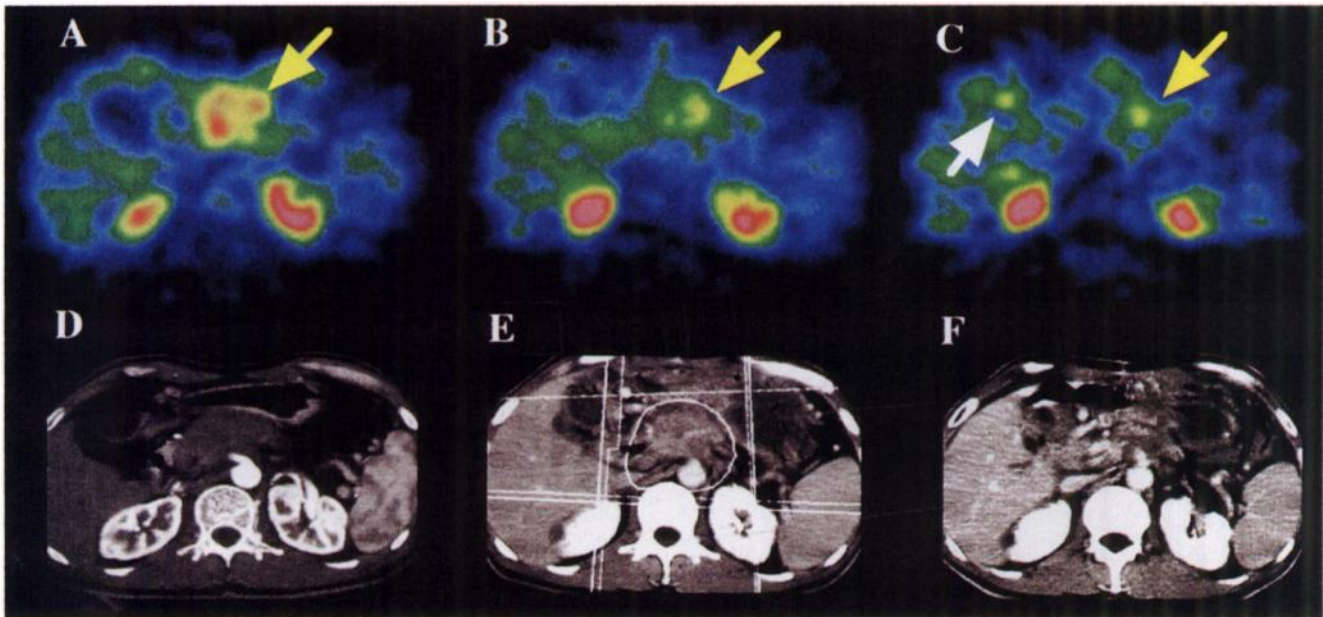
Patient 5, 51-y-old man with unresectable ductal adenocarcinoma. (A) PET before IORT shows remarkable focal FDG uptake in pancreatic body (yellow arrow) with maximum SUV = 4.34 using 10 × 10 mm ROI. (B) FDG uptake at 0.83 mo after IORT shows remarkable decreased area of tumor with maximum SUV = 3.23. (C) Follow-up FDG PET at 4.0 mo after IORT shows further decreased high uptake area at tumor site, but maximum SUV was still high (SUV = 3.2). In this intermediate period, liver metastasis was also detected (white arrow). Please note that highest uptake of tumor was observed in one more cephalic side of image in (B) and (C). (D) Contrast-enhanced CT shows low enhanced mass in pancreatic body. (E) Follow-up CT obtained at 0.73 mo after IORT revealed no change. (F) Follow-up CT at 4.0 mo after IORT shows 20% decreased tumor size, whereas it could not detect liver nodule.
